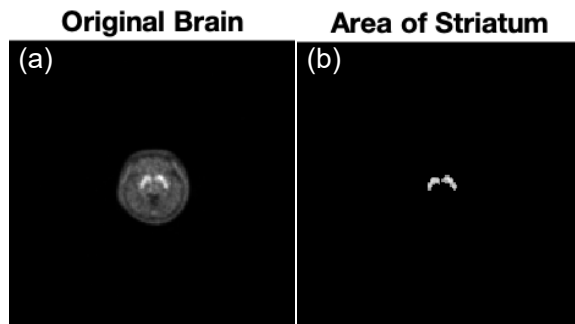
Image segmentation of patient No.3 by using Otsu's Algorithm with gray scale. (a) Original PET/CT imaging and (b) image segmentation of striatum.
